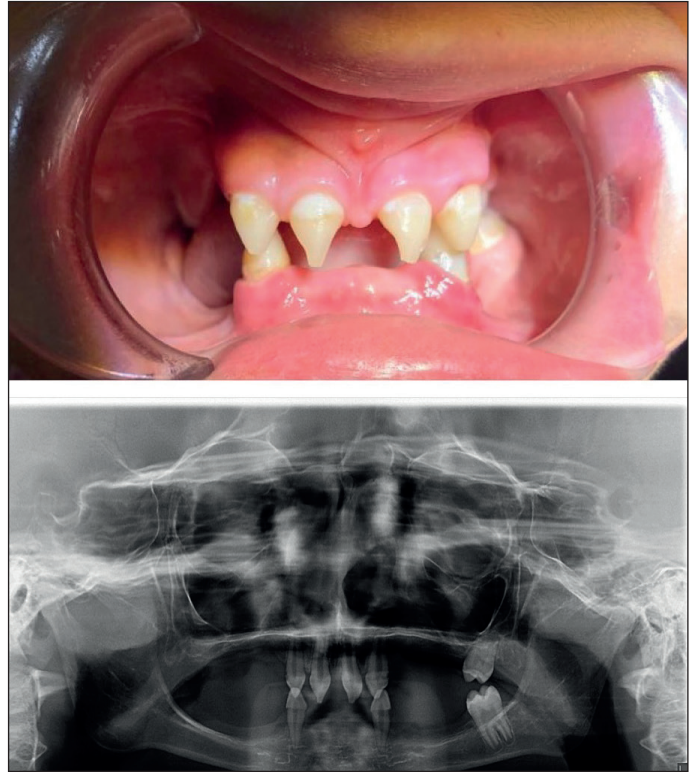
Clinical intra-oral frontal view of case 2. Panoramic radiograph revealing absence of 24 permanent teeth.
